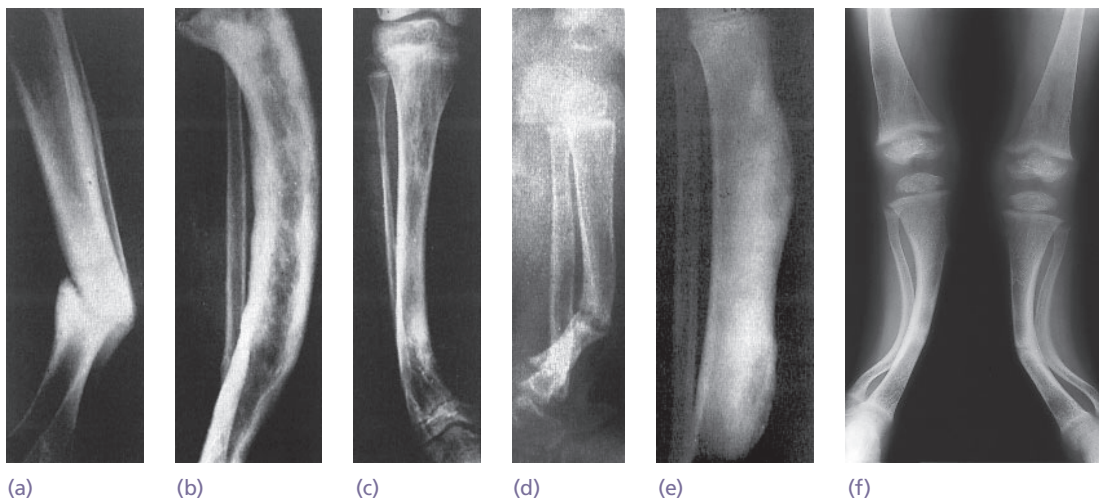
X-rays – bent bones (a) Malunited fracture; (b) Paget's disease; (c) dyschondroplasia; (d) congenital pseudarthrosis; (e) syphilitic sabre tibia; (f) osteogenesis imperfecta.
